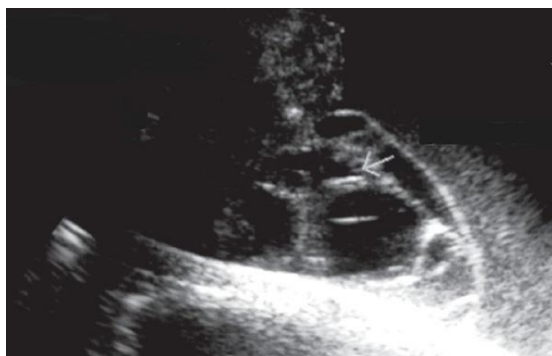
Ultrasonogram showing cystic mass with septations.
